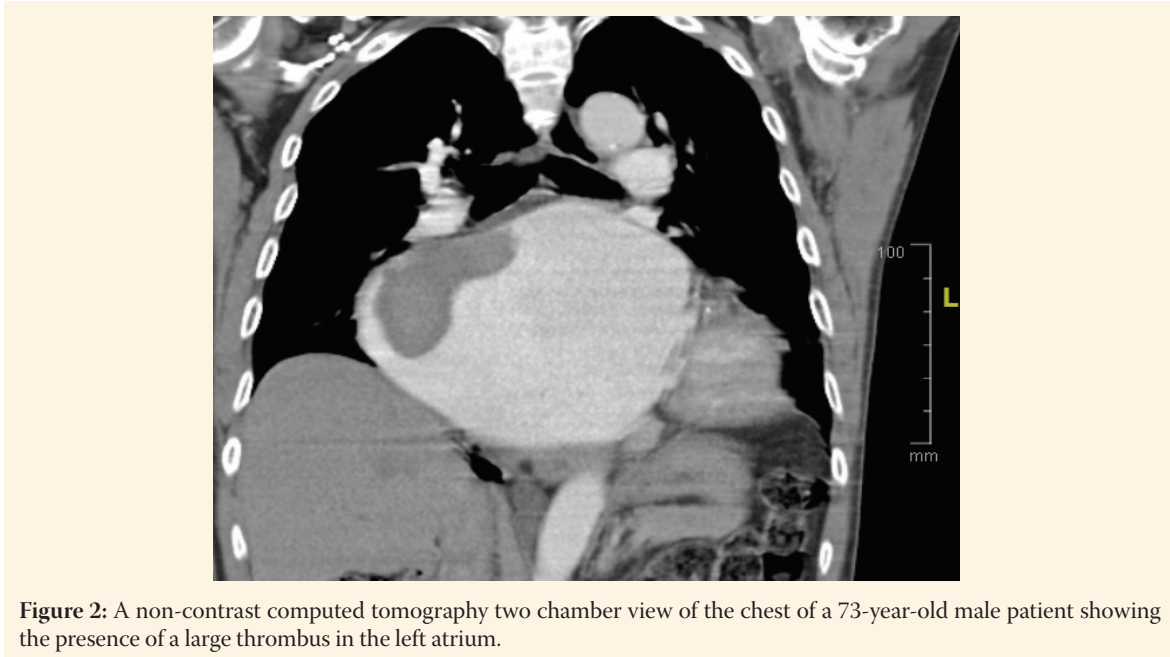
A non-contrast computed tomography two chamber view of the chest of a 73-year-old male patient showing the presence of a large thrombus in the left atrium.
